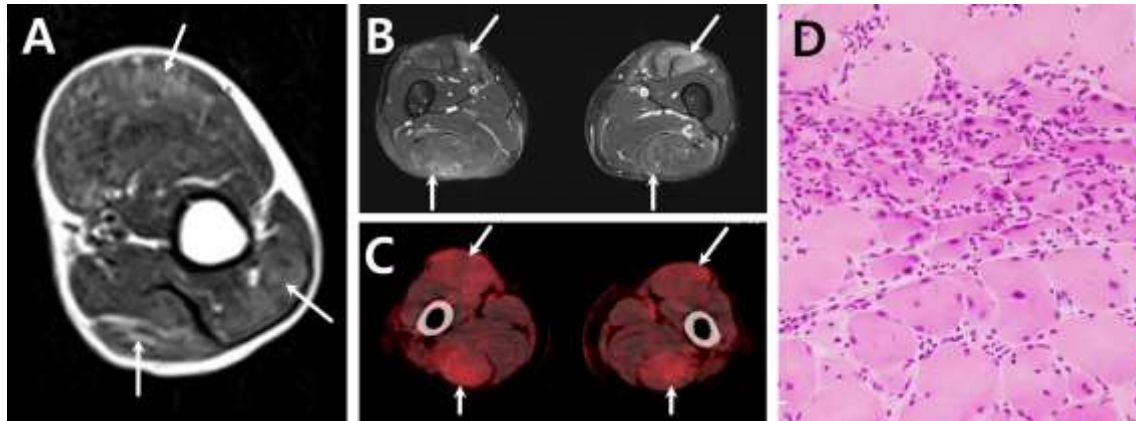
Results of imaging studies and biopsy. (A) Axial T2-weighted image on left upper arm MRI revealed signal changes in the biceps as well as the long and lateral head of the triceps (arrows). (B) Axial T2-weighted fat-suppressed turbo spin echo image on thigh MRI revealed increased signal intensity in the rectus femoris, semitendinosus, and biceps femoris muscles (arrows). (C) Positron emission tomography revealed increased uptake in the rectus femoris, semitendinosus, and biceps femoris muscles (arrows). (D) Biopsy of the right rectus femoris revealed markedly increased fiber size variation (20–100 μm), necrotic and regenerating fiber, internal nuclei, and inflammatory cell infiltration.
